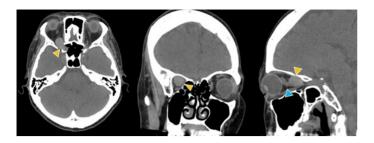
Plain CT revealed a uniform, mildly hyperdense lesion (yellow arrows) extending from the right orbit to the optic canal, compressing the optic nerve (blue arrow) downward and forward.
